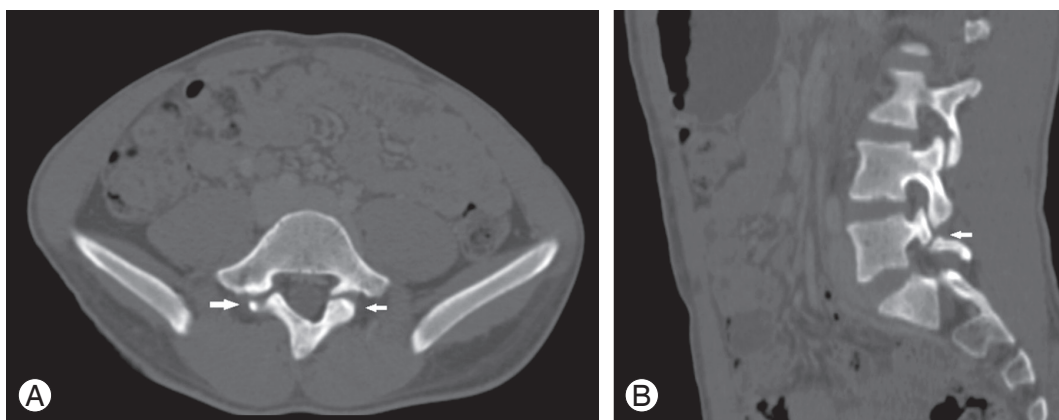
Computed tomography scan bone window image of a 19-year-old male presenting with abdominal pain. (A) Axial sections showing a bilateral break in the pars interarticularis (arrows). (B) Sagittal reconstructed image of the same patient showing a break of the pars interarticularis at the L5 level (arrow).
